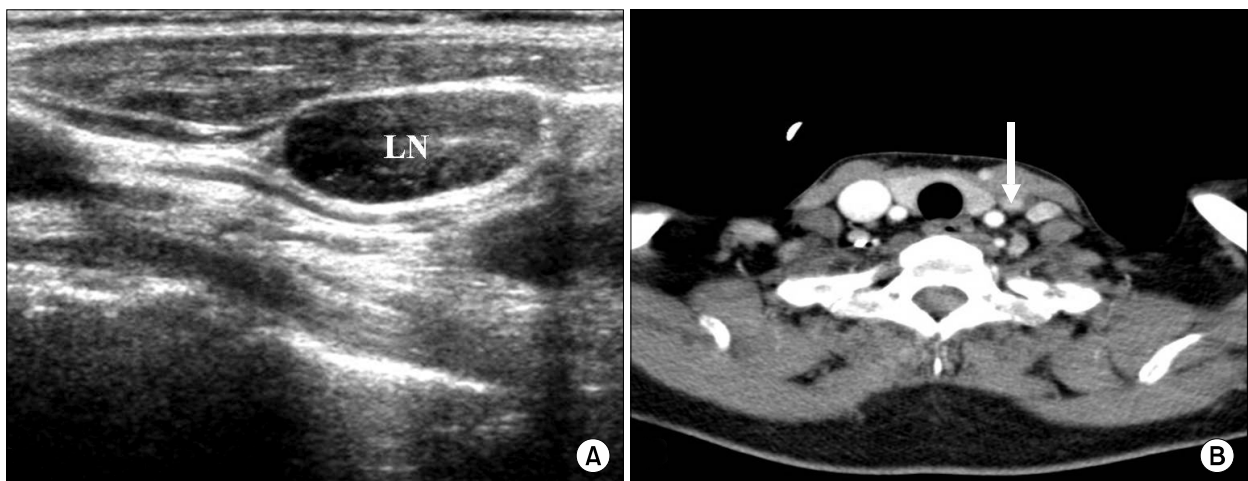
Cervical ultrasonography (A) and computed tomography (B) demonstrating the enlargement of left lateral lymph nodes (white arrow).
